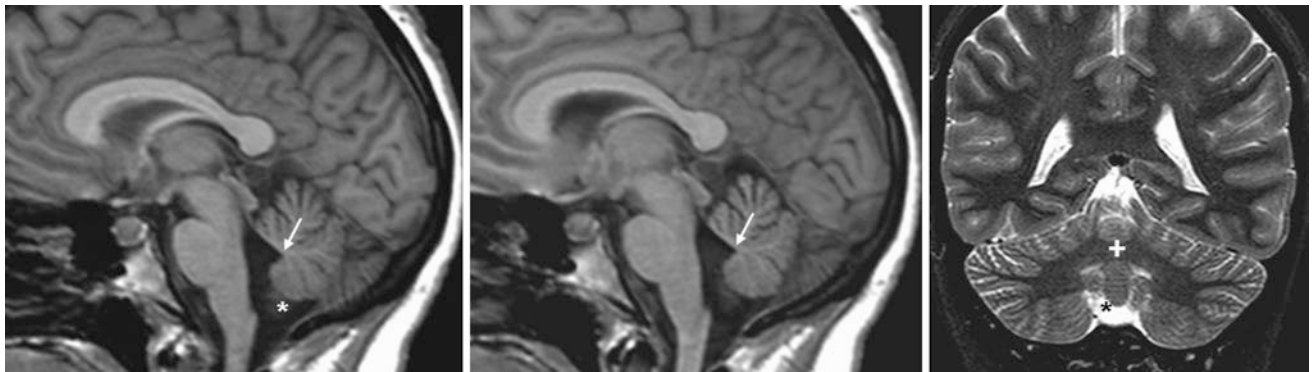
Comparison case of minimal Inferior cerebellar vermian hypoplasia (ICVH). A 28-year-old asymptomatic patient underwent a 1.5 T MRI that depicted a slightly prominent SAS below the vermian (*), with mild enlargement of the caudal portion of the fourth ventricle and a normal
